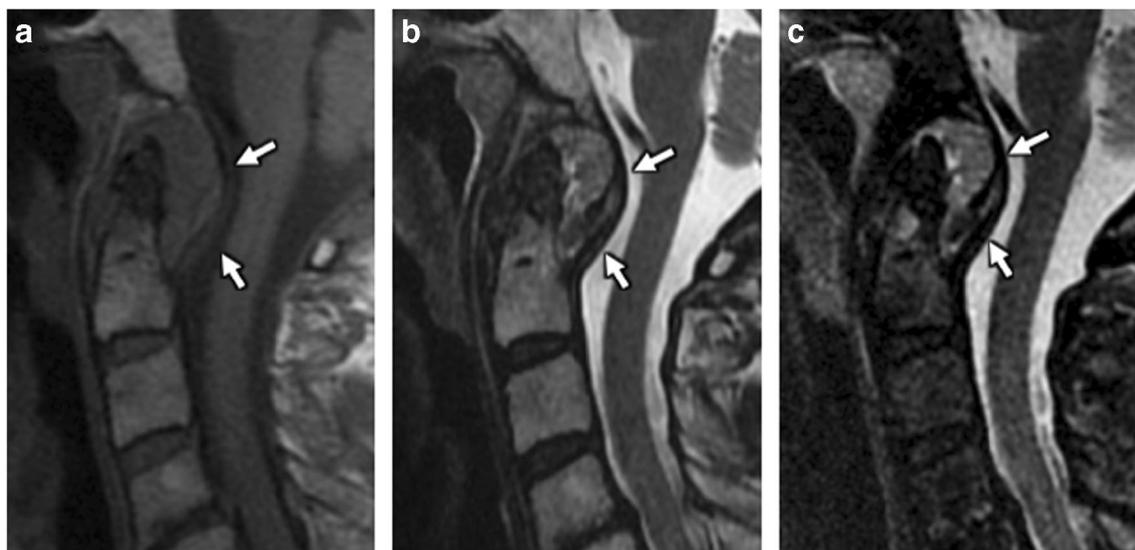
a A 68-year-old man with history of long-standing rheumatoid arthritis with “pannus-type” pseudotumor, which tends to enhance and has also been called “hypervascular pannus” when contrast is administered. Sagittal T1-weighted image demonstrates T1 isointense (to brain)
